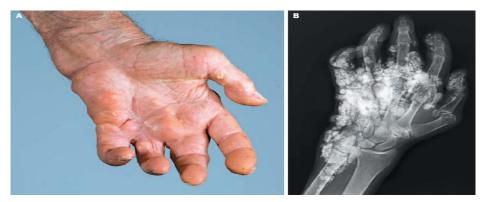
Calcinosis cutis in systemic sclerosis: Physical examination revealed extensive soft-tissue calcification involving both hands and all the fingers, with bilateral flexion deformities and unhealed ulcers of the distal digits that drained calcific deposits (Panel A). Extensive calcinosis cutis was also observed on plain radiographs of the hands (Panel B)
